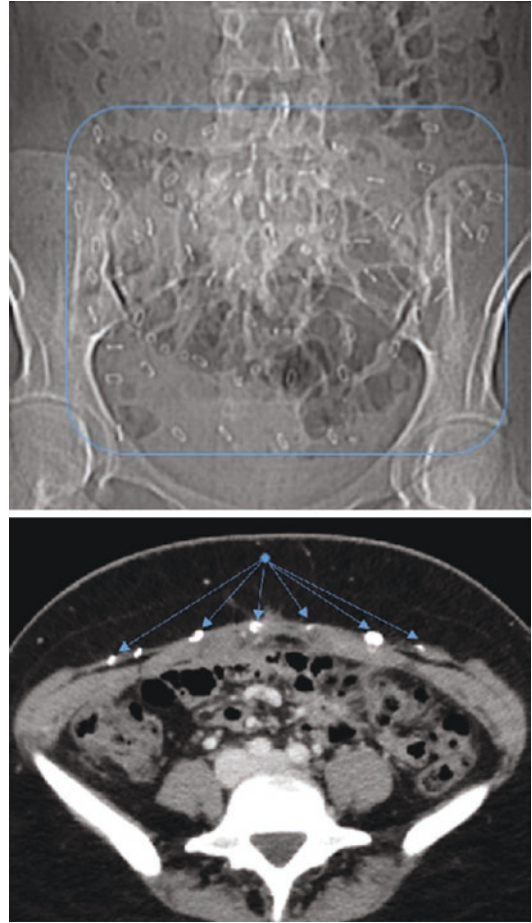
A 40 year old female with prior open onlay mesh repair following abdominal wall resection of endometrial deposits. Plain abdominal X-ray demonstrates staples used to secure the mesh to the abdominal wall (blue outline). CT imaging confirms the mesh is placed in the onlay fashion based on the location of staples above the rectus muscles. In this situation, future abdominal access could be planned above the superior edge of the mesh with the expectation that intra-abdominal adhesions would not be affected by the prior mesh repair
